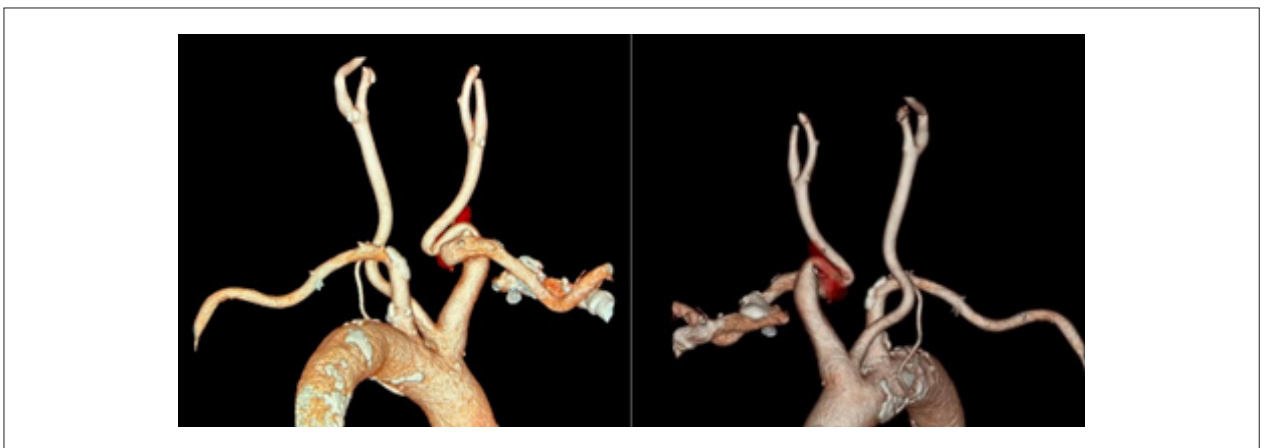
3D computed tomography angiography of the neck showing right subclavian artery and right common artery kinking.
